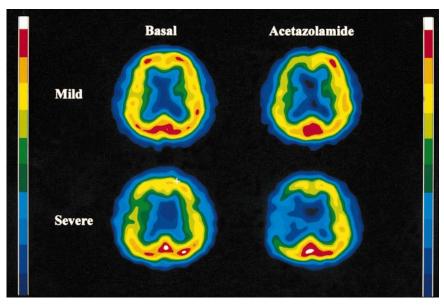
Severity of reduced rCVR on ^{99m}Tc-ECD ACZ-SPECT. Mild grade indicates reduced rCVR with abnormal distributions that fell into 1 color range from basal SPECT after ACZ administration (10%– 20% change). Severe grade indicates reduced rCVR with drop of at least 2 color ranges from basal SPECT after ACZ administration (>20% change).
